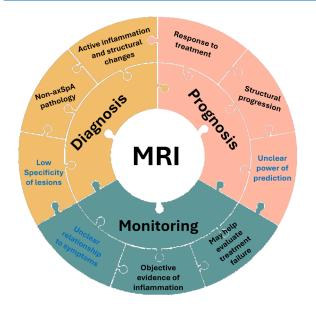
The role of MRI in axial spondyloarthritis
